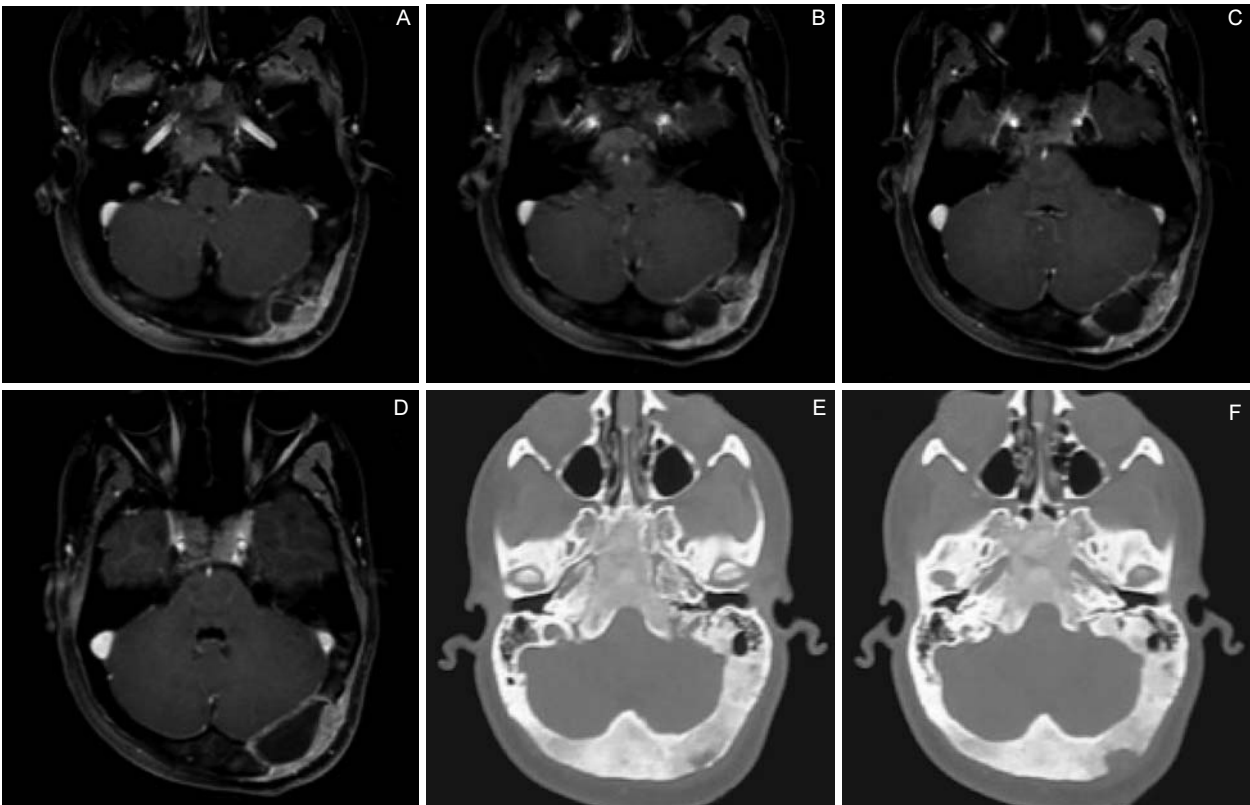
Female aged 21 with swelling in left occipital region and headaches. Fibrous dysplasia: axial sequences of MR (A, B, C, D) with T1-weighting using gadolinium, showing the structure of the lesion and the voluminous cyst. Same patient in axial CT (E, F) sequences with bone window. Detail showing the “frosted glass” appearance of the skull.
